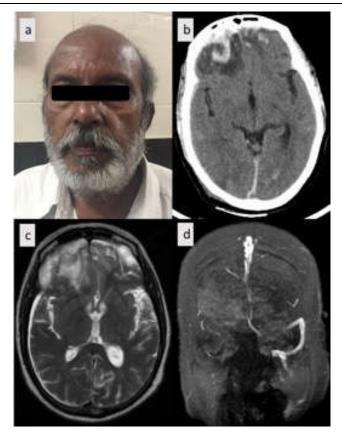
Clinical photograph, CT brain, MRI Brain & MRV of Case 1
